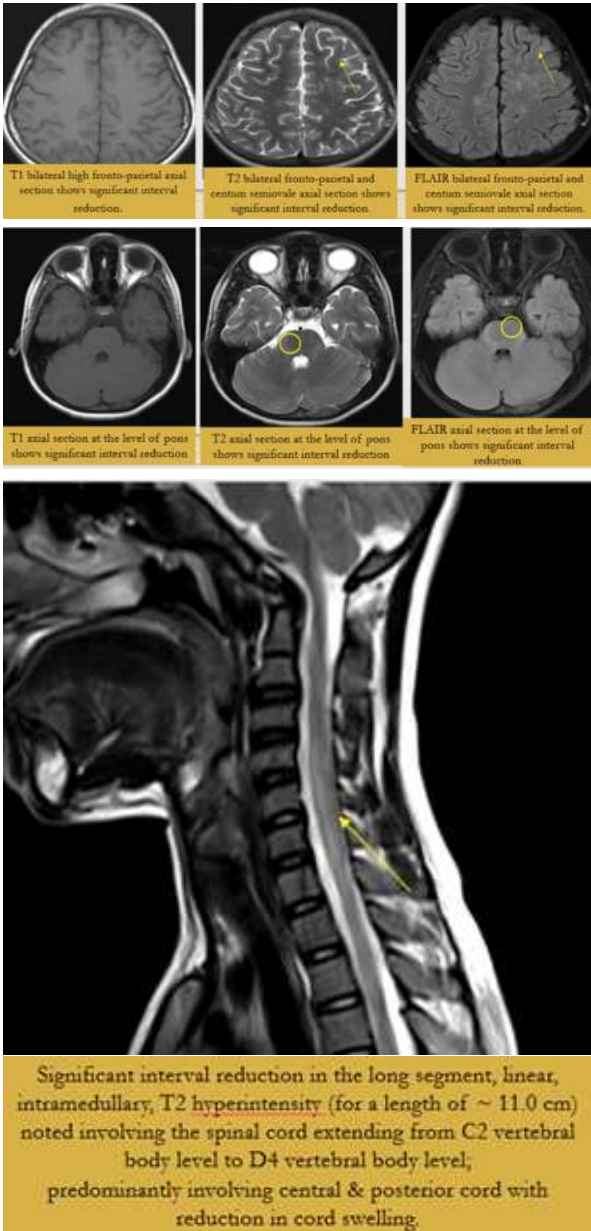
5 & 6 showing post treatment MR images of.
